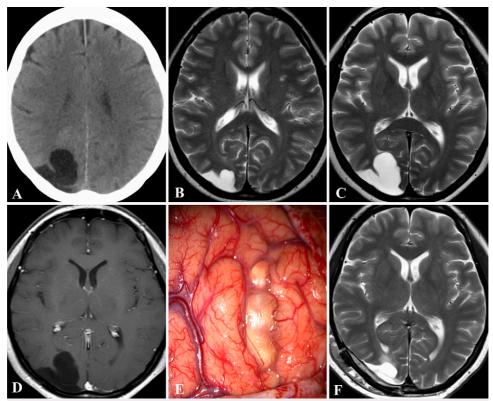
Computed tomography image showed a low-resolution cystic lesion in the right occipital lobe (A). Initial T2-weighted MRI showed a hyperintensity area (B). The lesion grew over the course of 8 years (C). T1-weighted gadolinium-enhanced MRI showed no enhancement in the lesion or the surrounding tissue (D). An intraoperative photograph showed the cyst covered by a shiny membrane containing a clear, colorless fluid (E). Postoperative MRI showed that the cyst with high intensity on T2-weighted images had shrunk (F).
